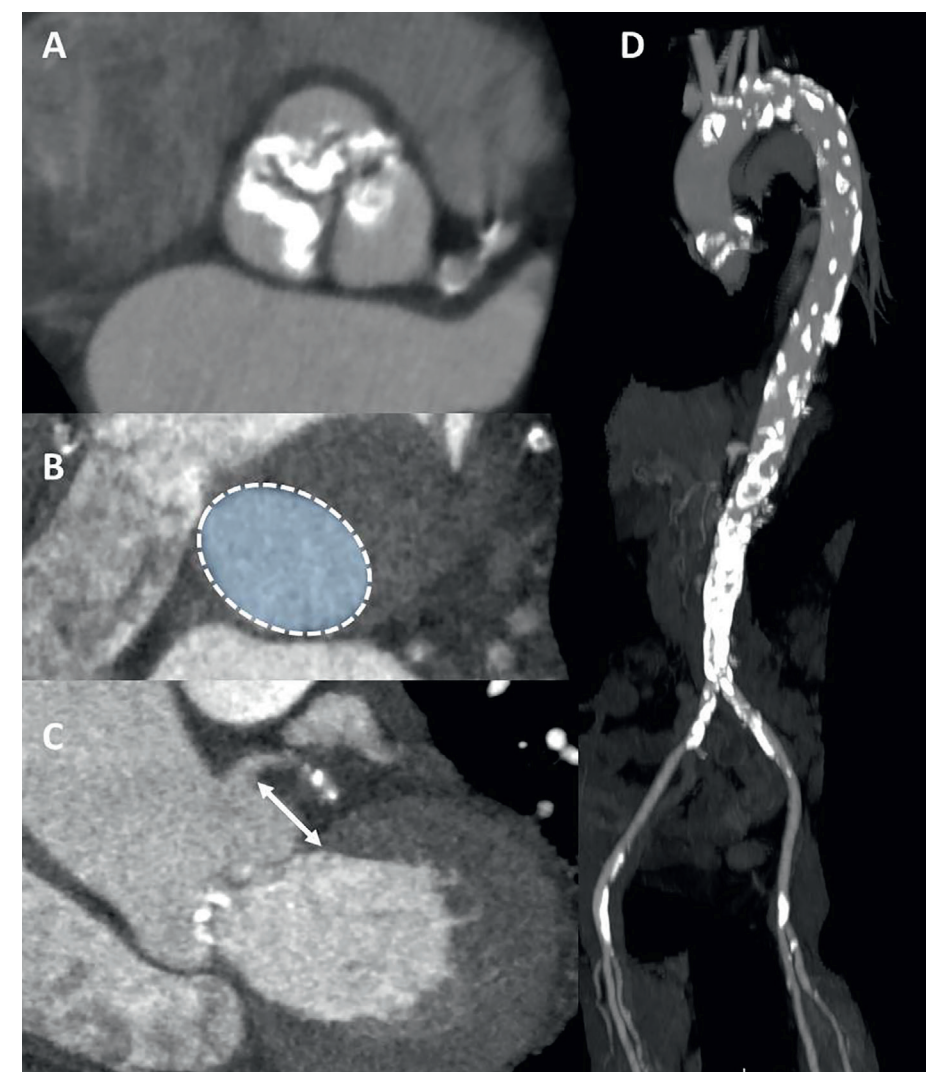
The role of multidetector row computed tomography (MDCT) in preprocedural assessment. (A) Double oblique transverse view of severely calcified tricuspid aortic valve. (B) Planimetry of the aortic annulus. (C) Measurement of the distance between the left main coronary artery and the aortic annulus (white arrow). (D) CT aortography reveals severely calcified aorta, particularly in the aortic arch and in the descending part. Calcifications are present in both iliofemoral arteries as well.
